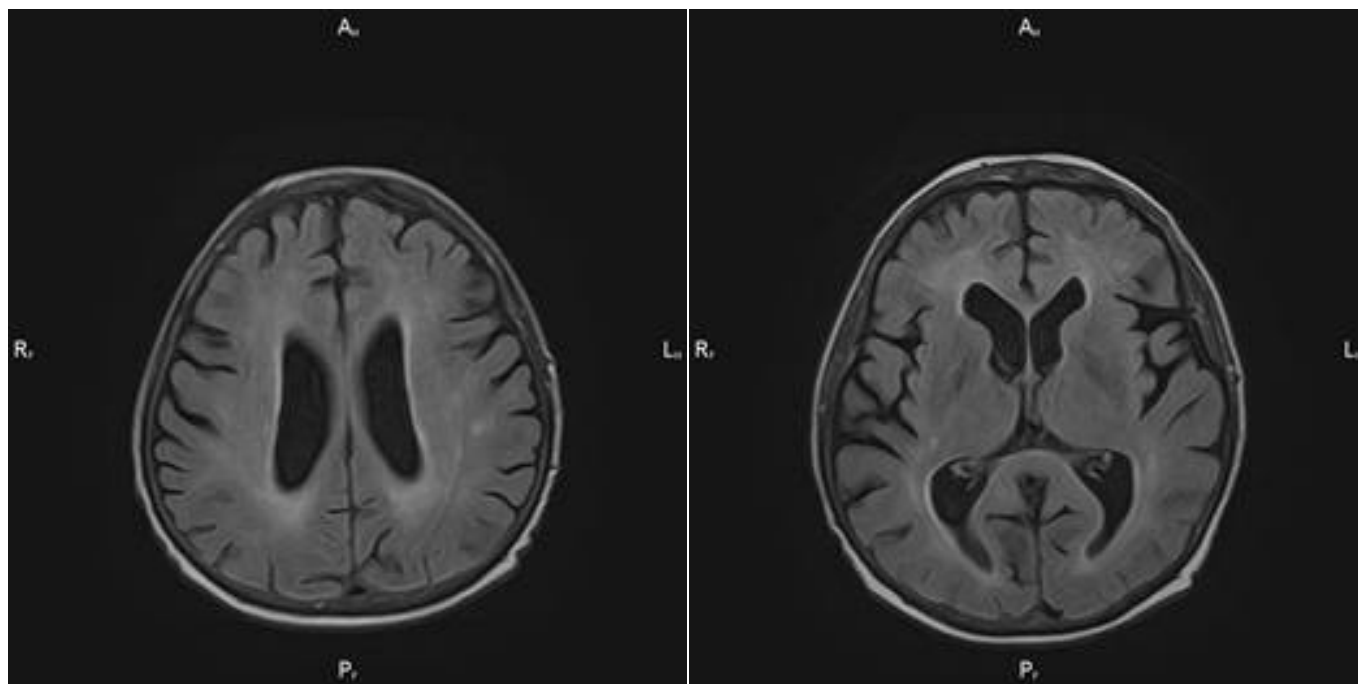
Cerebral MRI showing ventriculomegaly.
